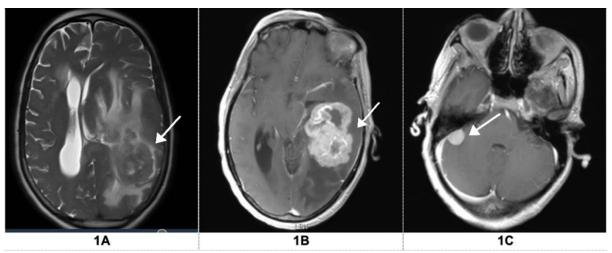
A Brain MRI with contrast preoperatively showed a large multilobulated intra-axial mass involving the left parietal and temporal lobes (8.6 X 5 X 6 cm) with central cystic degeneration, necrosis and surroundings with significant vasogenic oedema with a midline shift of 1.45 cm. B: mass effect on the left lateral ventricle and left cerebral peduncle effacing the left ambient cistern. C: An incidental finding of a right tentorial small meningioma
